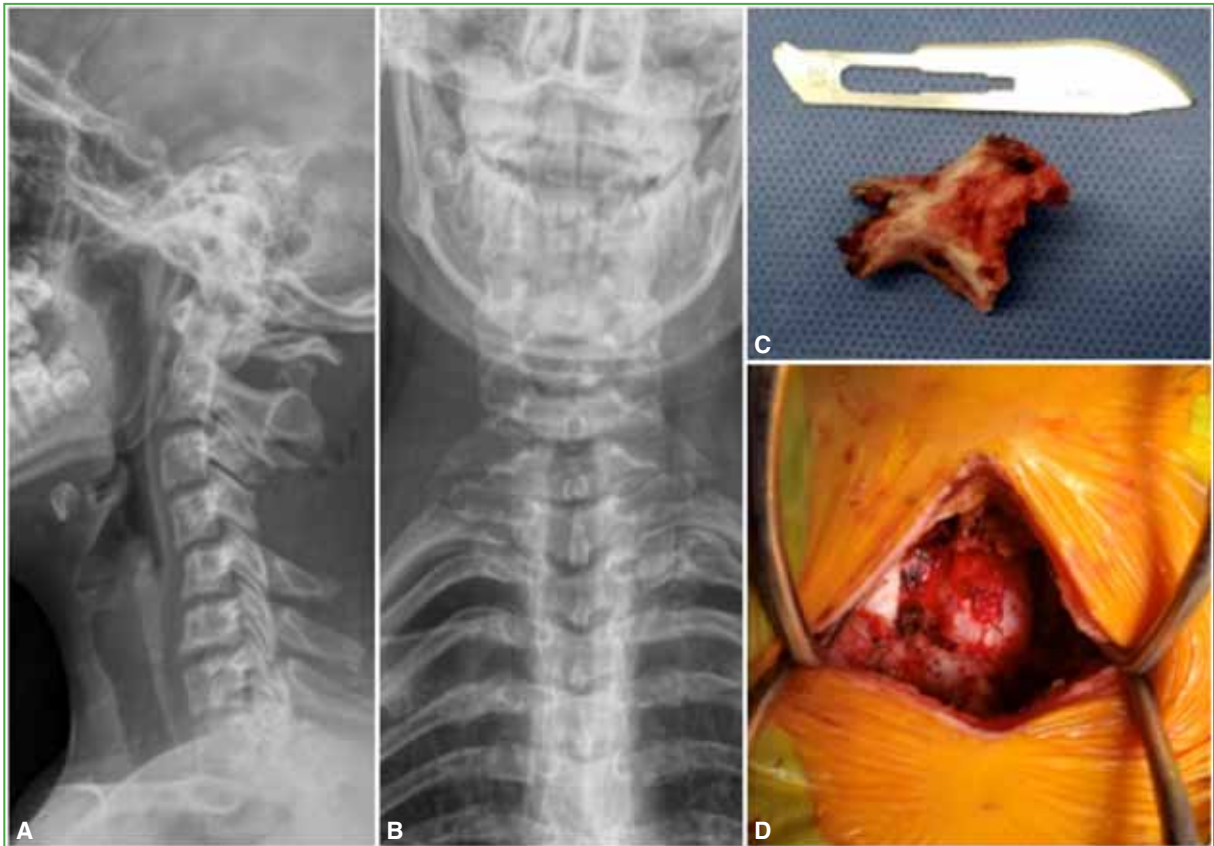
Anteroposterior and lateral radiographs of the cervical region in the immediate postoperative period (A and B) and image of the resection of the posterior arch of C4 (C and D).
